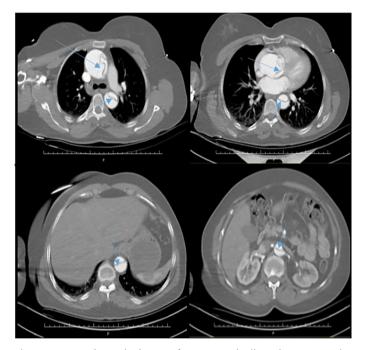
CT angiography image of type 1 aortic dissection. We see the dissection line in different sections (blue arrow)
